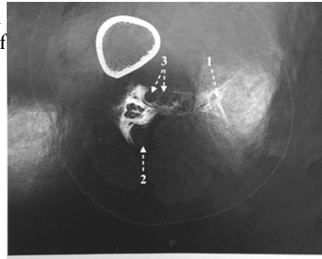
Computed tomography scan cross-sectional view of the lower limb. Shown is distal spread of contrast (1), sciatic nerve (2), and popliteal vessels (3).
